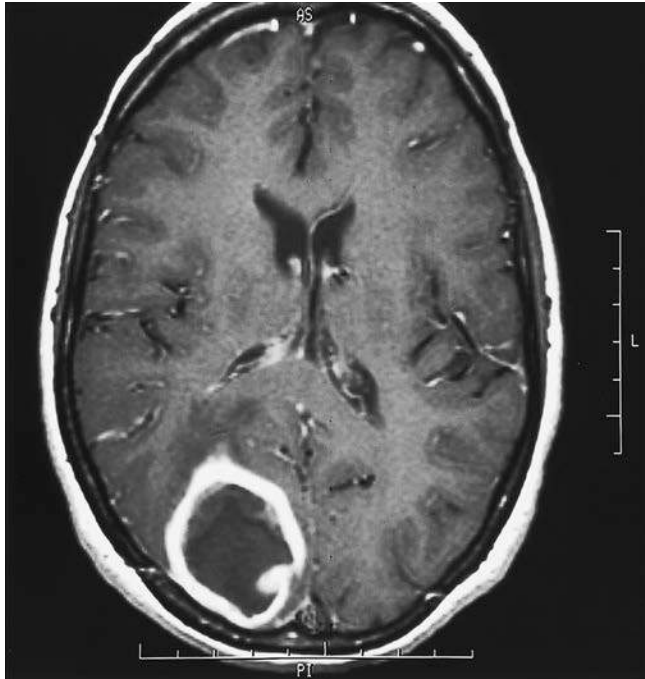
Cerebral abscess in a 33-year-old woman with cyanotic and pulmonary hypertensive congenital heart disease. Axial T1-weighted postcontrast magnetic resonance image shows an abscess (*Streptococcus intermedius*, 5 × 3.6 × 3.6 cm in diameter) in the right occipital lobe. Typical contrast enhancement of the abscess wall and perilesional edema are present. (Courtesy A. Valavanis, Institute of Diagnostic Neuroradiology, University Hospital, Zurich, Switzerland.)
